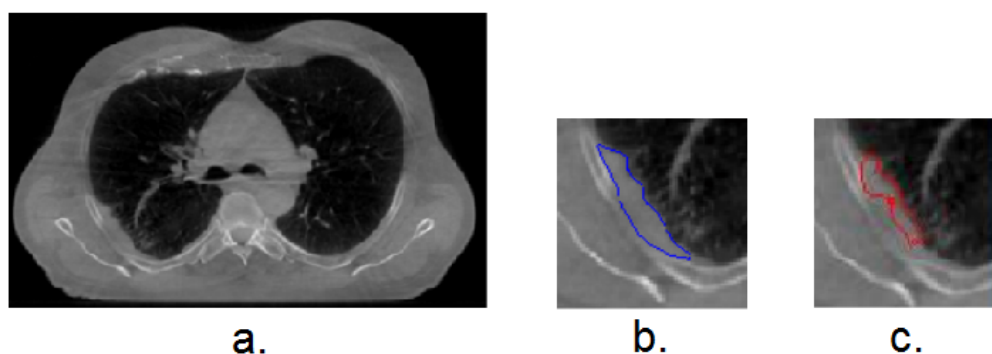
The proposed Model g on CBCT#10 Patient 25, where the red contour is the result of level set.
